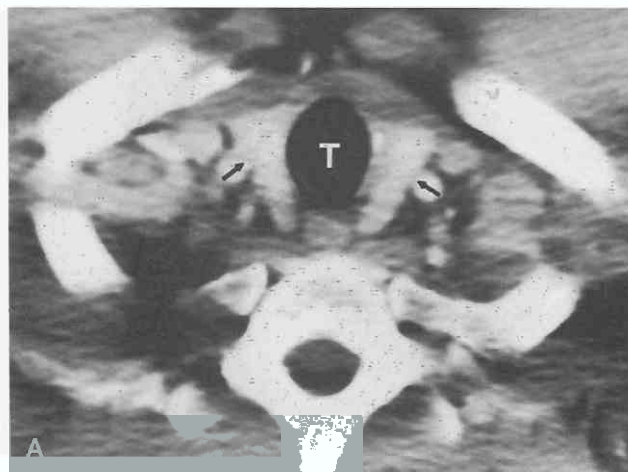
Normal thyroid gland. A, Contrast-enhanced CT shows typical appearance of thyroid gland (arrows). Enhancement is homogeneous. T, trachea. B, T1-weighted axial MR image shows homogeneous intermediate signal intensity typical of normal thyroid gland (arrows). T, trachea.
